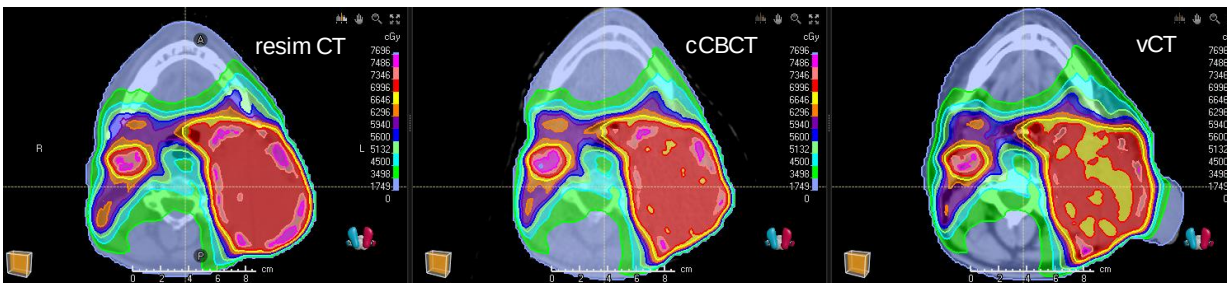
Dose distributions of the same plan calculated on different CT sets for the patient shown in Fig. 1.
